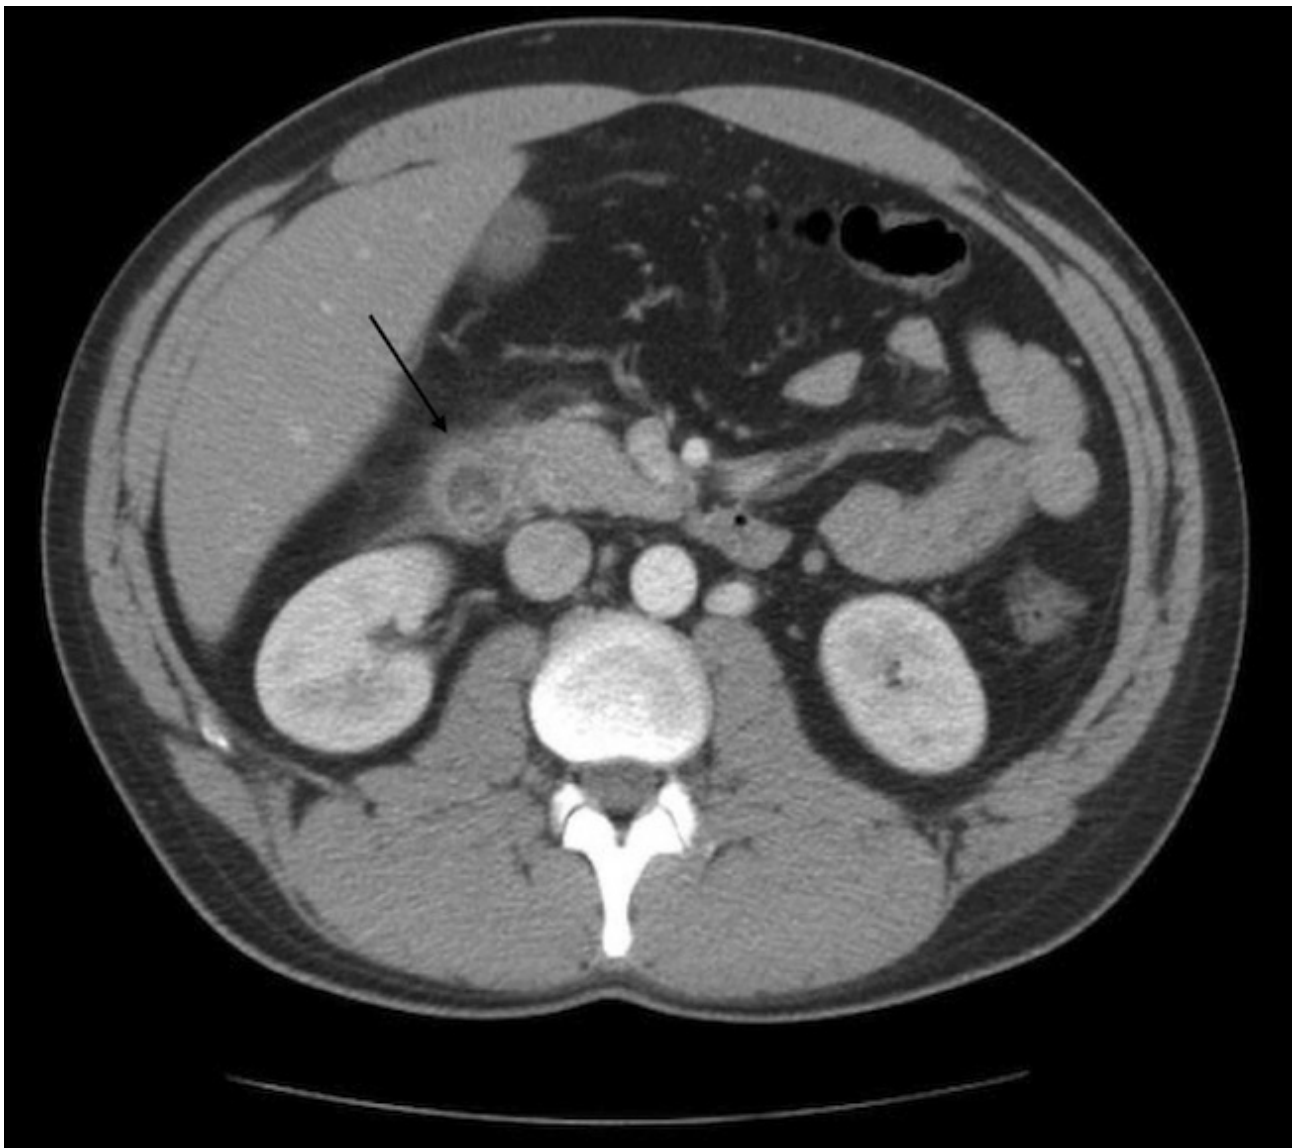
CT scan of the abdomen on day 0 showing an inflamed duodenum (arrow).
